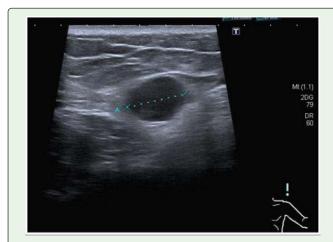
Ultrasound showing a nodular lesion in the belly of teres minor.
